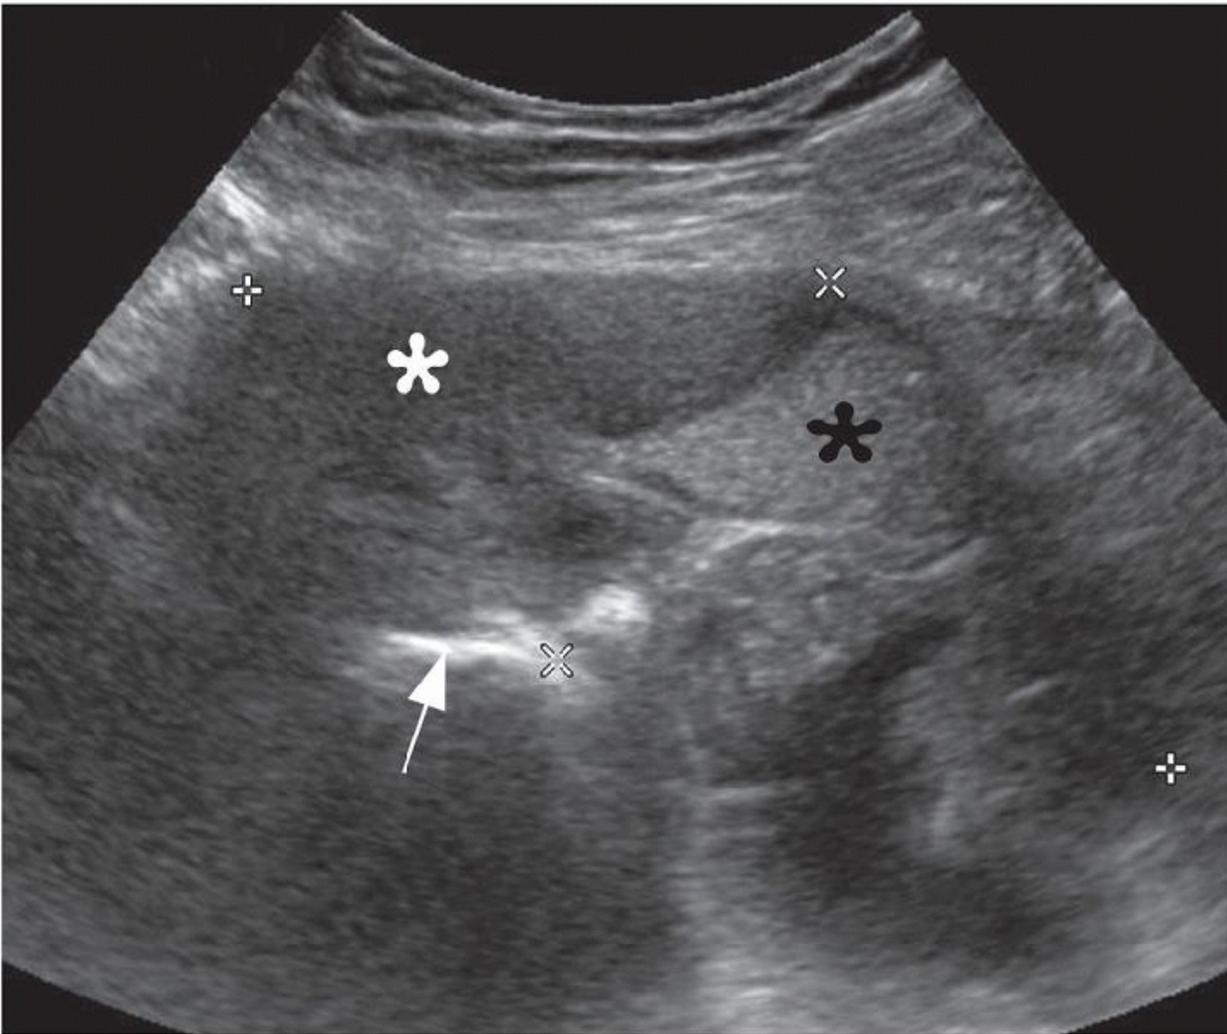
ALVAL. Longitudinal sonogram along the anteromedial femoral neck shows typical mixed solid (black asterisk) and cystic (white asterisk) lesion (calipers) adjacent to the hyperechoic edge of the resurfaced hip (arrow).
